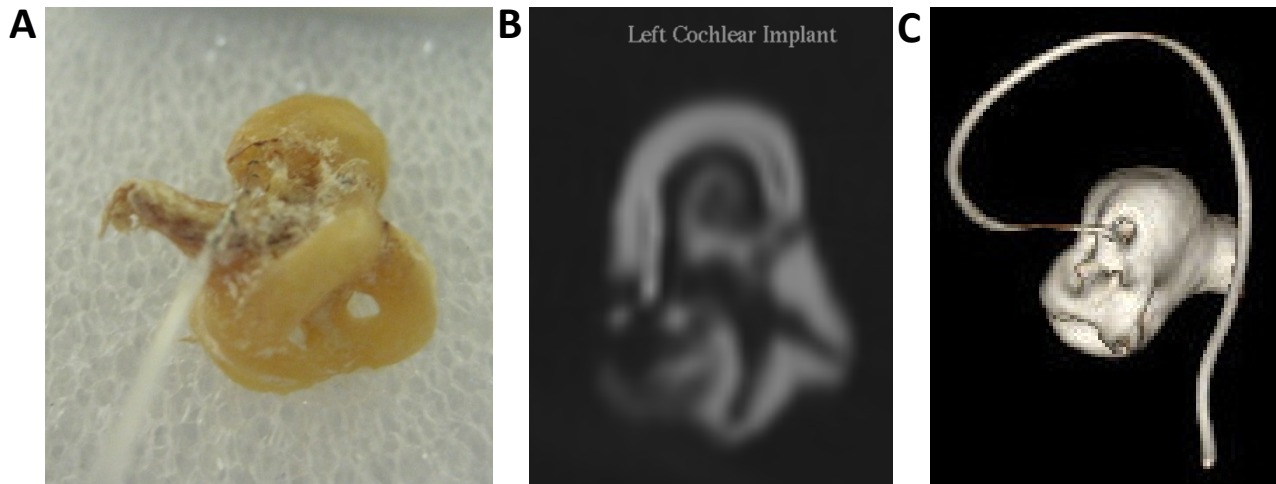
(A) Cochlea post-implantation of the TFM/IP. (B) Fluoroscopy image of TFM/IP implanted cochlea. (C) CT scan 3D reconstruction of TFM/IP implanted cochlea.
